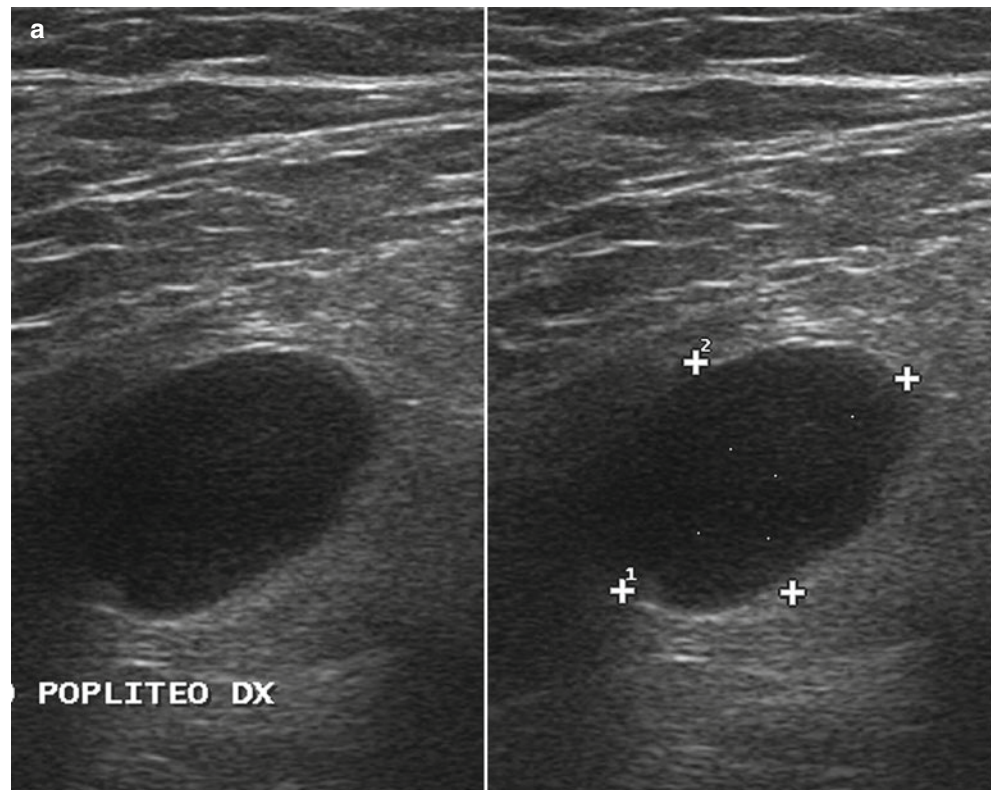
Fine-needle aspiration cytology (FNAC) of an interval popliteal lymph node. A 18–13 hypoechoic popliteal nodule is detected at follow-up in a patient with history of foot melanoma (*a caliper*). Confirmatory ultrasound-guided FNAC is subsequently performed. Note the needle (*b arrows*) penetrating obliquely into the nodule
